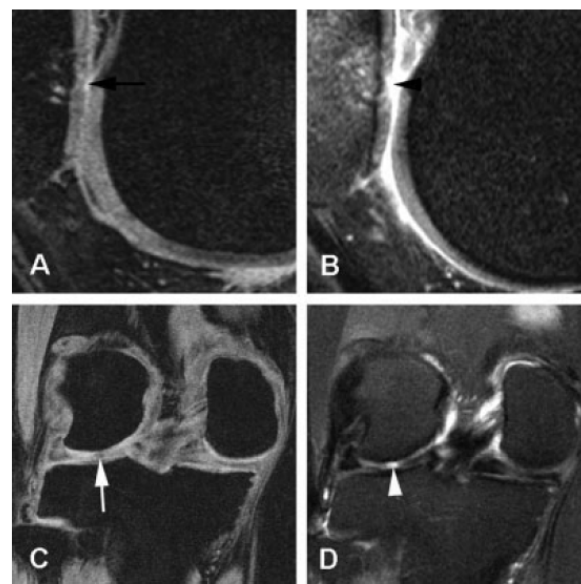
A and B, Focal superficial defect in the retropatellar articular surface. Sagittal double-echo steady-state (T2-weighted gradient-recalled echo [GRE]-type sequence) image barely depicts surface abnormality (A) (arrow). Due to arthrographic effect, the defect is better visualized on sagittal intermediate-weighted fat-suppressed image (B) (arrowhead). C and D, Full thickness defect in the central weight-bearing region of the lateral femur. Coronal fast low-angle shot (T1-weighted 3-dimensional GRE-type sequence) image shows discrete hypointensity in the cartilage matrix, not to be assessed as a defect, that could potentially be read as an artifact such as truncation or susceptibility (arrow) and slight motion artifacts can be noted, due to long imaging time (9 minutes 35 seconds) (C). Coronal T2-weighted fat-suppressed image clearly depicts full-thickness defect, due to excellent contrast between cartilage and intraarticular fluid (D). (Images in A and B from the Osteoarthritis Initiative study and C and D from the Framingham Osteoarthritis study.)
